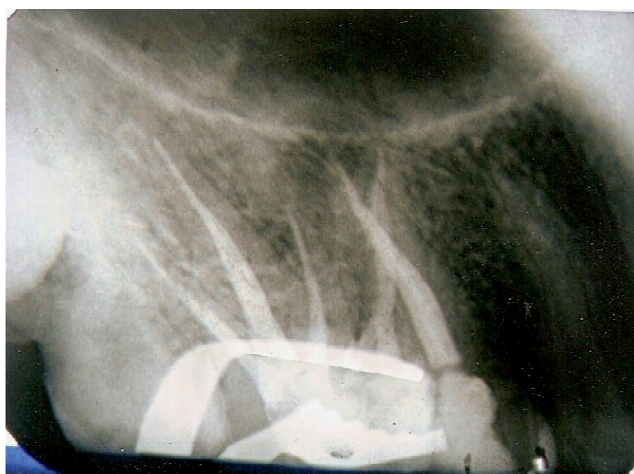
Radiograph taken immediately after obturation shows two separate palatal roots in case of tooth 16 while the tooth 15 shows only one root and one canal.
